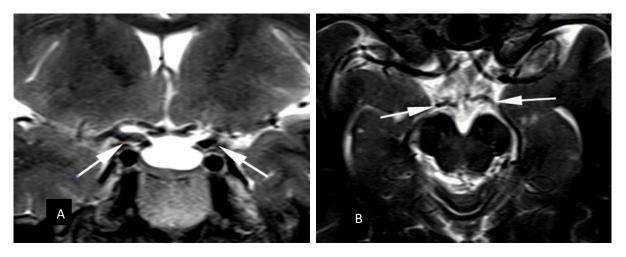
Coronal and axial T2 weighted MR images in the same patient show expected flow voids that imply permeability in A: the supraclinoid and terminal segments of the internal carotid artery, and (B) in the first segment of the posterior cerebral arteries.
